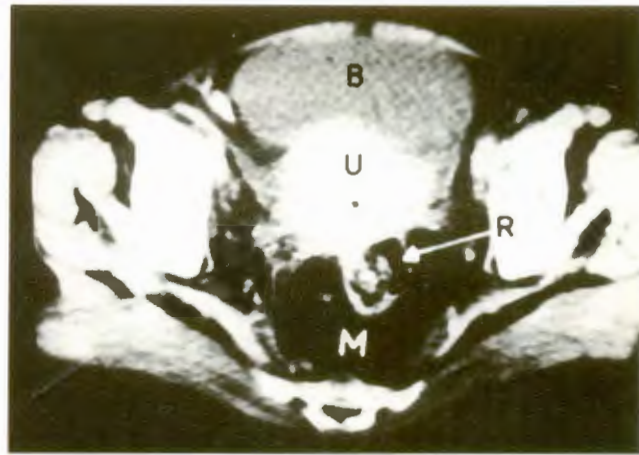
CT-Scan Pelvis Showing Space Occupying Lesion
